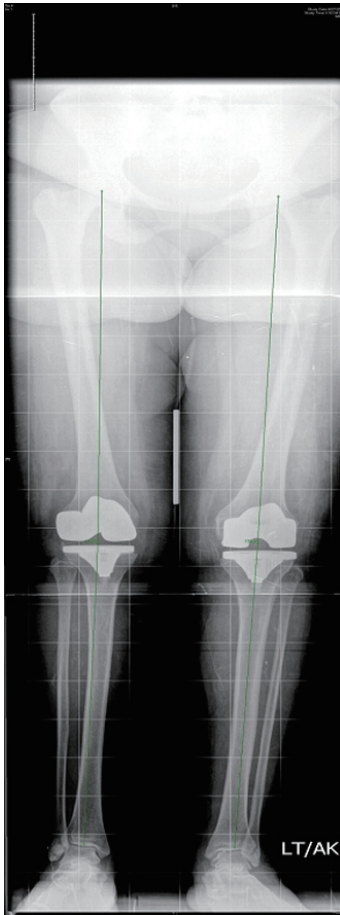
Postoperative weight bearing long leg radiograph measuring the hip-knee-ankle angle axis (mechanical axis).
